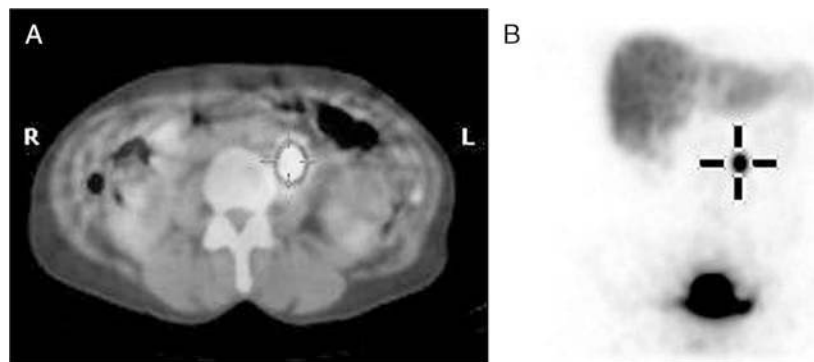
SPECT/CT (A) and MIP image (B) showing 1 hot spot identified as an isolated para-aortic SLN after PT injection.
